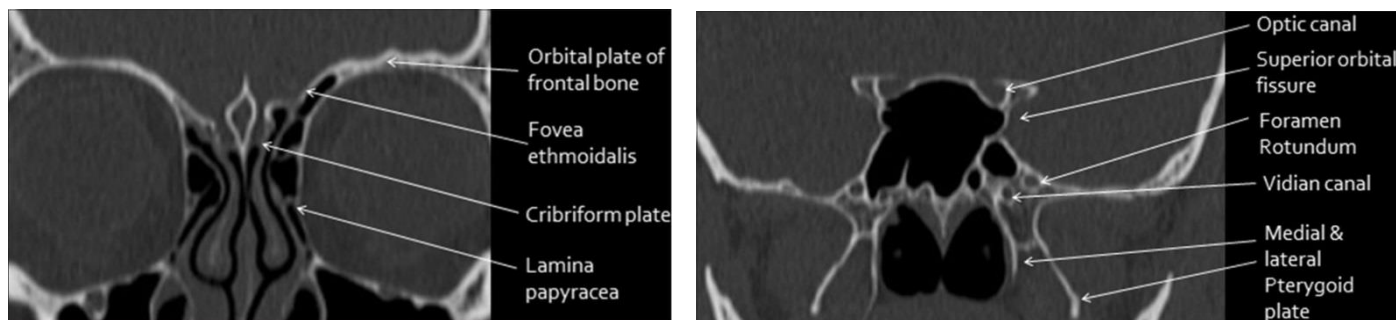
Critical structures surrounding the paranasal sinuses as demonstrated in coronal CT scans of nose and paranasal sinuses.
